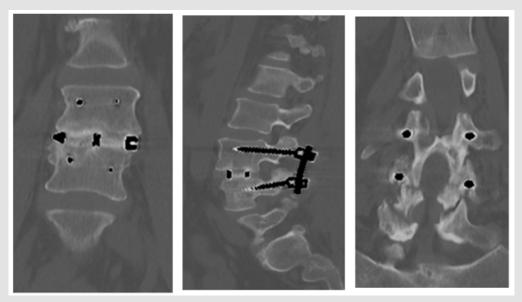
8-month post-op CT Scans show early interbody and posterolateral fusion success.
